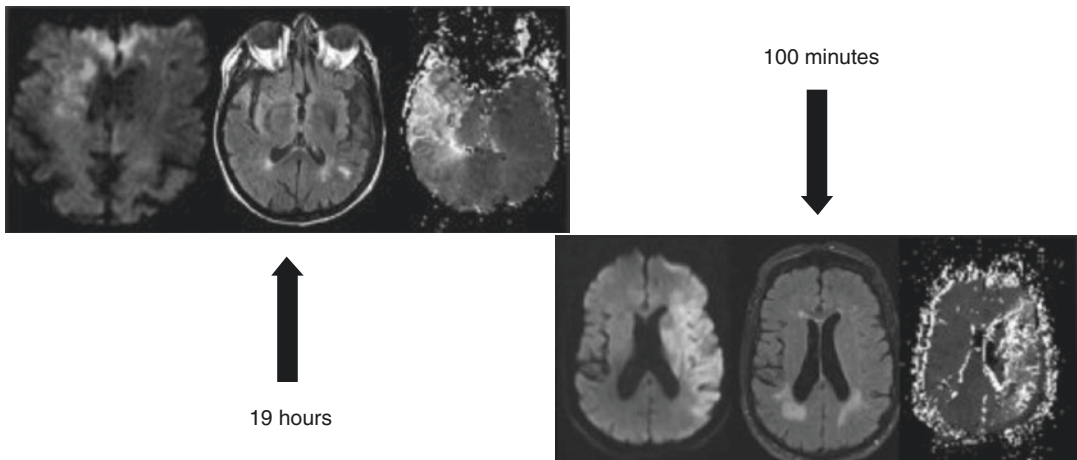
DWI lesion poorly correlates with time of onset. Detailed imaging of acute middle cerebral artery stroke (left to right: diffusion-weighted imaging, fluid-attenuated
